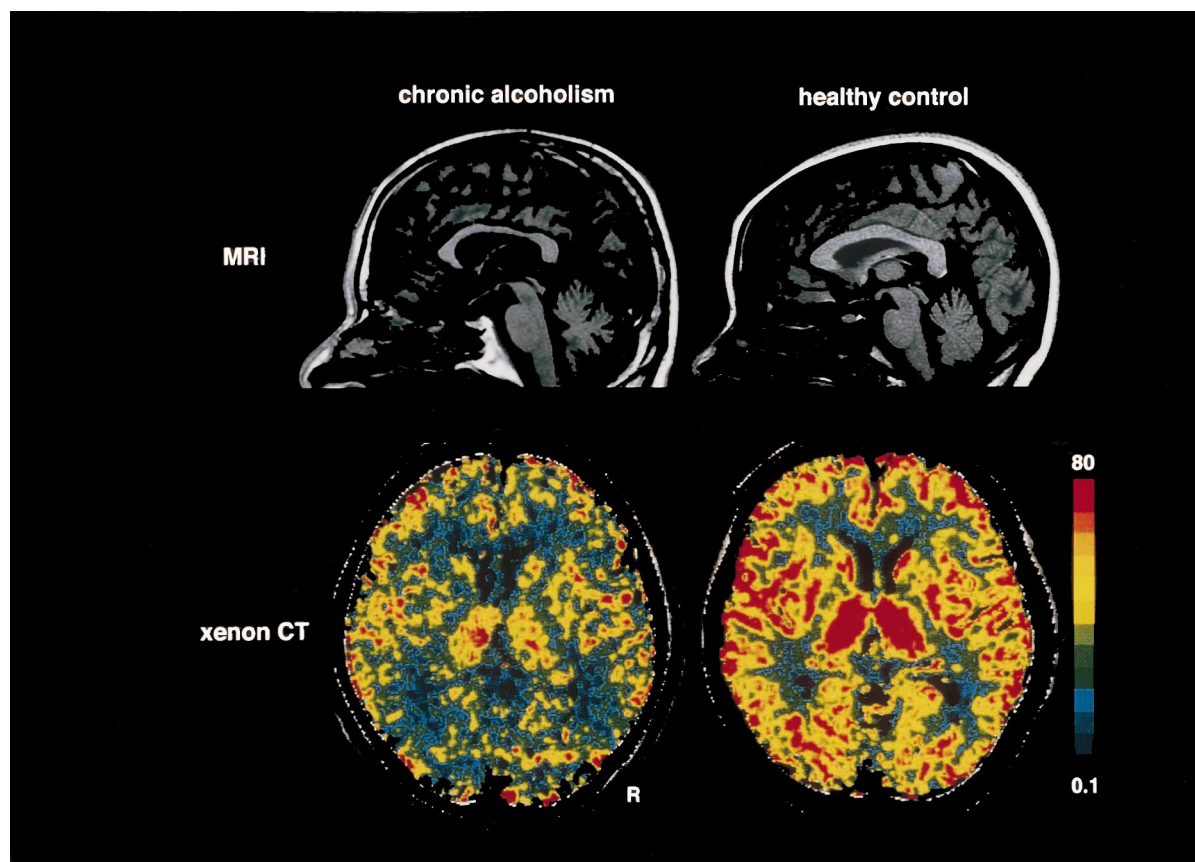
The T1-weighted images of MRI and cerebral blood flow images of xenon CT in a chronic alcoholic and a healthy control. The corpus callosum atrophy and decreased cerebral blood flow were noted in a chronic alcoholic.
